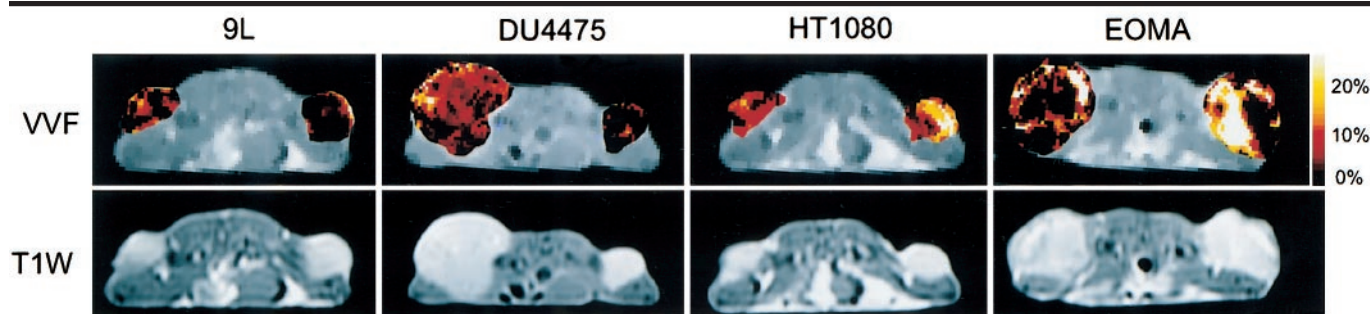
MR images of the four experimental tumor models. Top row: Color-coded VVF tumoral vascularity maps are superimposed onto the tumors and derived from pre- and postcontrast T2*-weighted MR imaging sequences. VVF values are from 0% to 30%. Note the heterogeneity of VVF among the tumor models. Bottom row: The different tumors are outlined on postcontrast T1-weighted spin-echo MR images (300/6).
